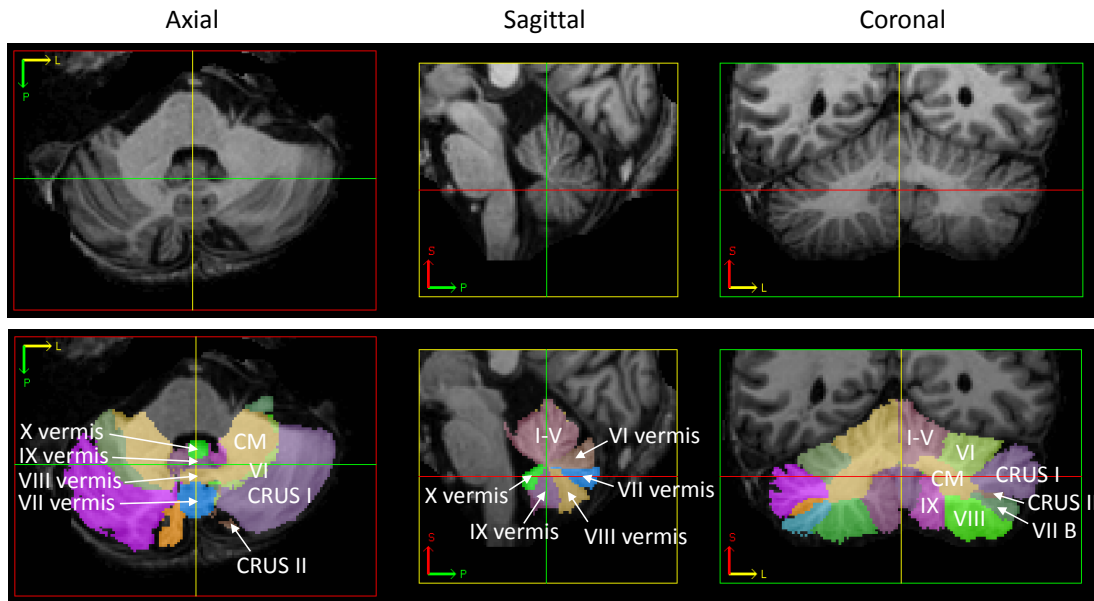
Annotated examples of the cerebellar lobules in three different views. The top and bottom rows are MR images overlaid with expert delineated lobules from a healthy control and an ataxia patient, respectively.
